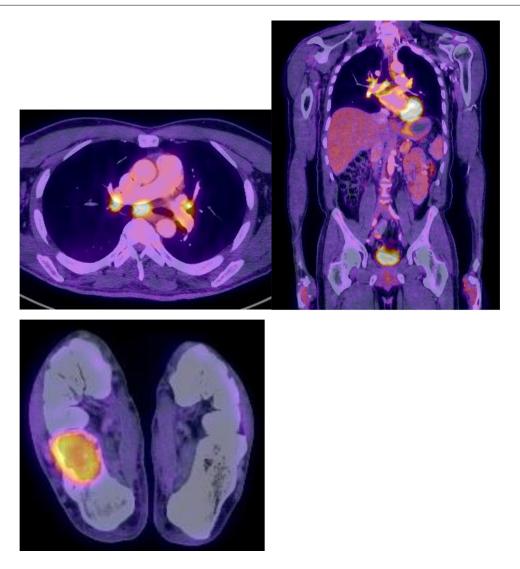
Axial and coronal PET-CT image shows hypermetabolic mediastinal lymph nodes and the hypermetabolic calcaneal lesion
